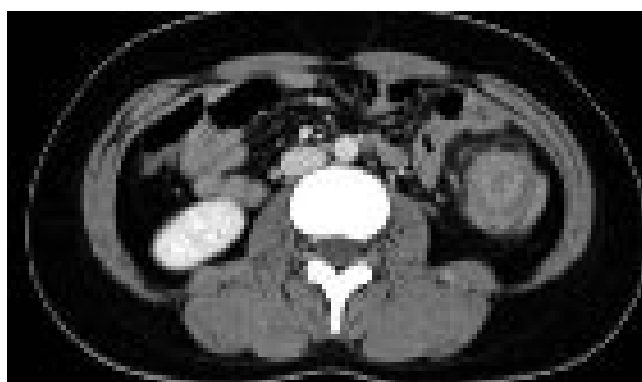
Computed tomography shows the cystic lesion in the descending colon, occupying the whole lumen, and also shows multicentric target sign and sausage-shaped inhomogeneous soft-tissue mass.
